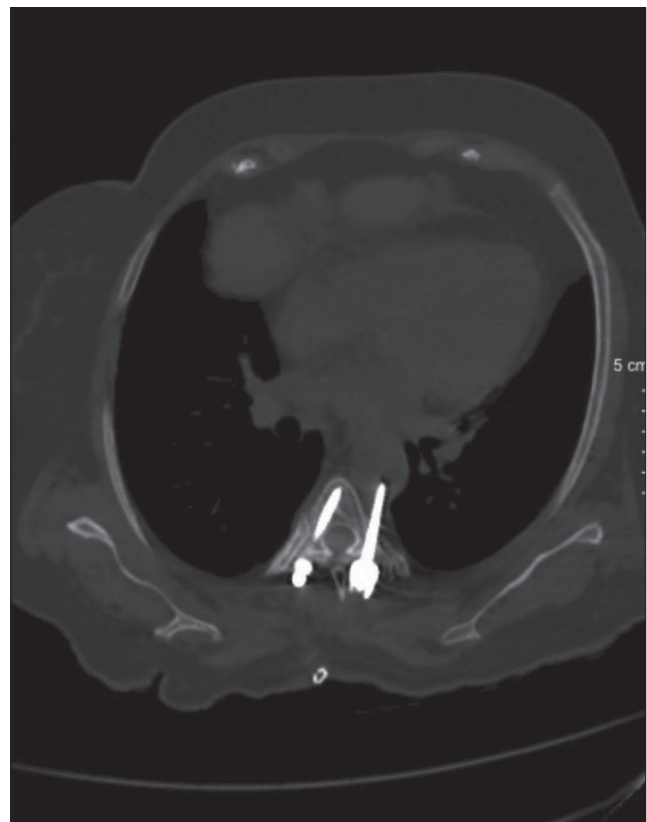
Axial computed tomography scan of the thorax demonstrating a malpositioned left-sided pedicle screw at the T5 level in close proximity to the descending thoracic aorta. The screw is seen penetrating the left lateral aspect of the vertebral body, creating an indentation on the adjacent aortic wall, indicating direct contact and risk of vascular injury.
